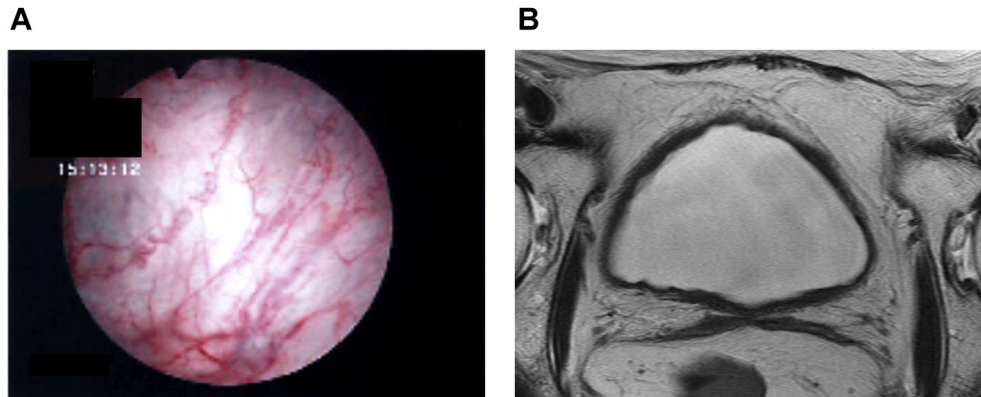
Cystoscopy and pelvic MRI 5 years after the radiotherapy. Cystoscopy after the treatment showed normal bladder mucosa (A). MRI showed no bladder mass (B). T2-weighted image.
